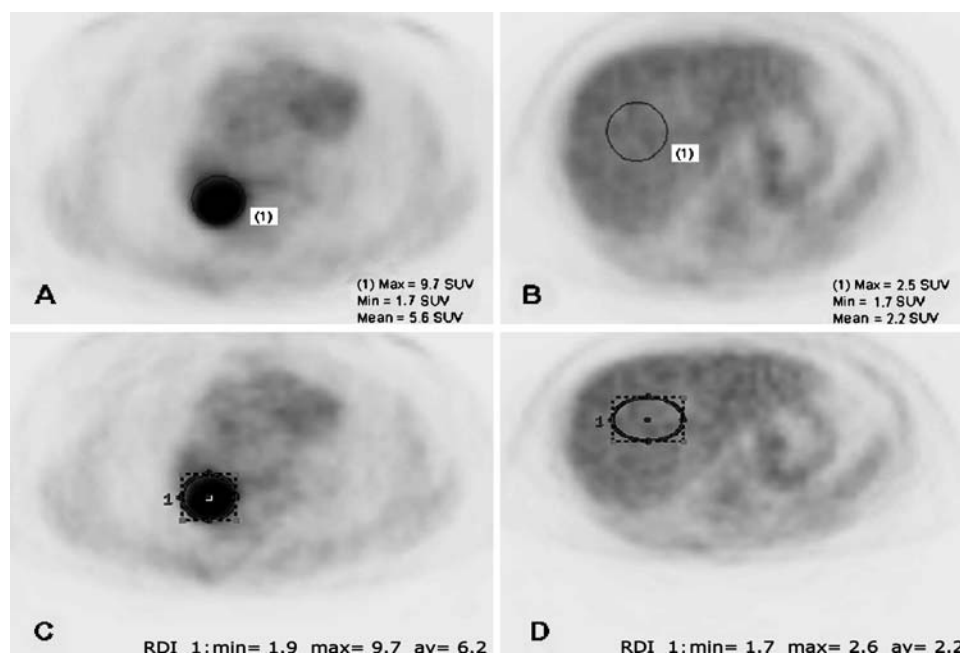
SUV measurements of a right lower lobe lung mass and of the liver parenchyma performed at dedicated (A–B) and AWS PACS-integrated (C–D) workstations.
